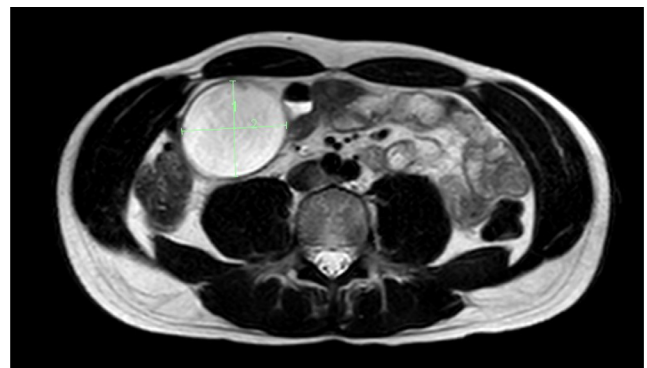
Axial T-2 weighted MRI abdomen-pelvis demonstrating a tubular lesion with T-2 hyperintensity situated adjacent to the caecum / ascending colon.
